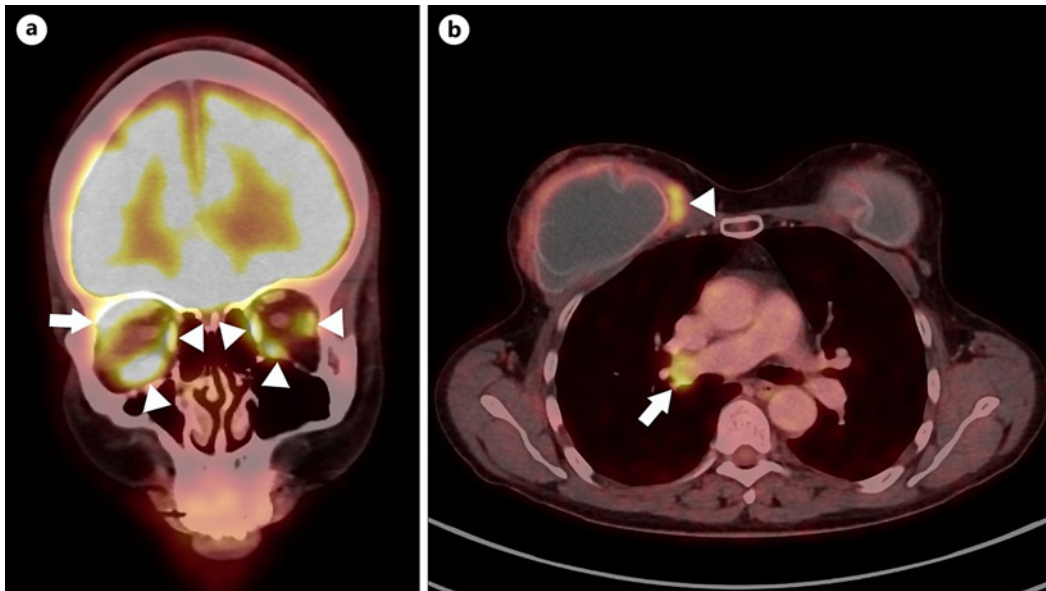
a ^{18}F -FDG PET-CT of the face with pathological uptake in orbital muscles bilaterally (arrowheads) and left lacrimal gland (arrow). b ^{18}F -FDG PET-CT of the thorax with pathological uptake surrounding ruptured silicone breast implant (arrowhead) and in lymph nodes in the right pulmonary hilus (arrow).
